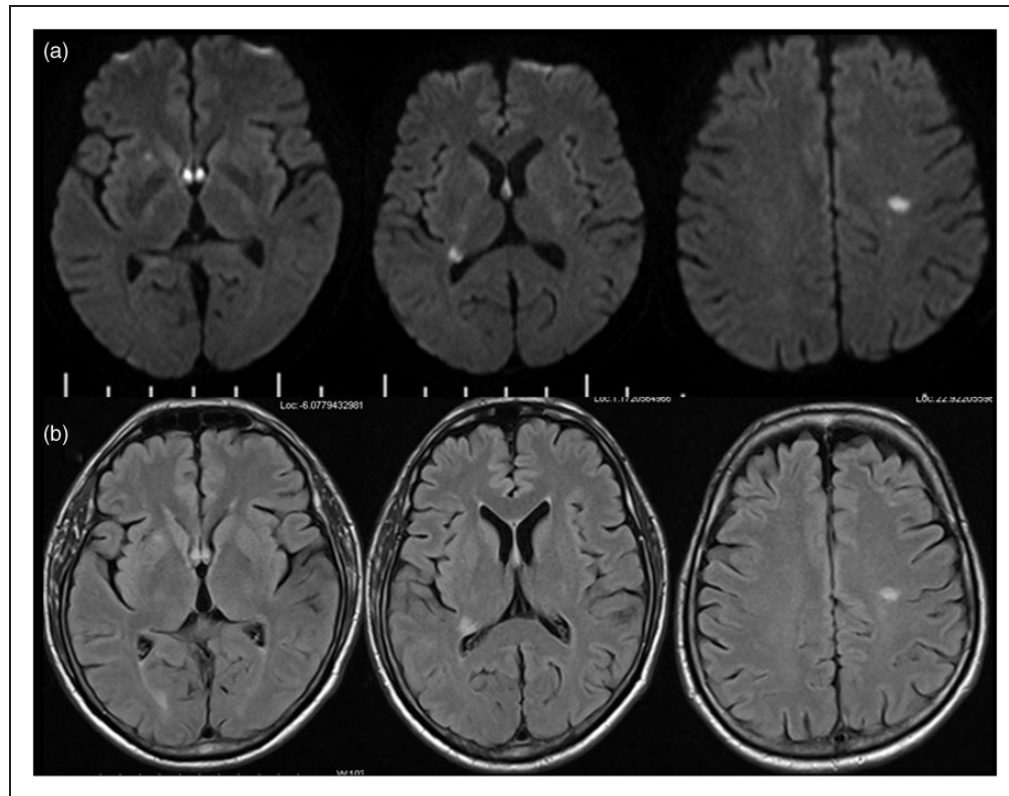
(a) shows restricted diffusion on diffusion weighted image (DWI) in bilateral fornix, right peritrigonal, right putamen and left corona radiata with corresponding fluid attenuation inversion recovery (FLAIR) hyperintensities in (b).
